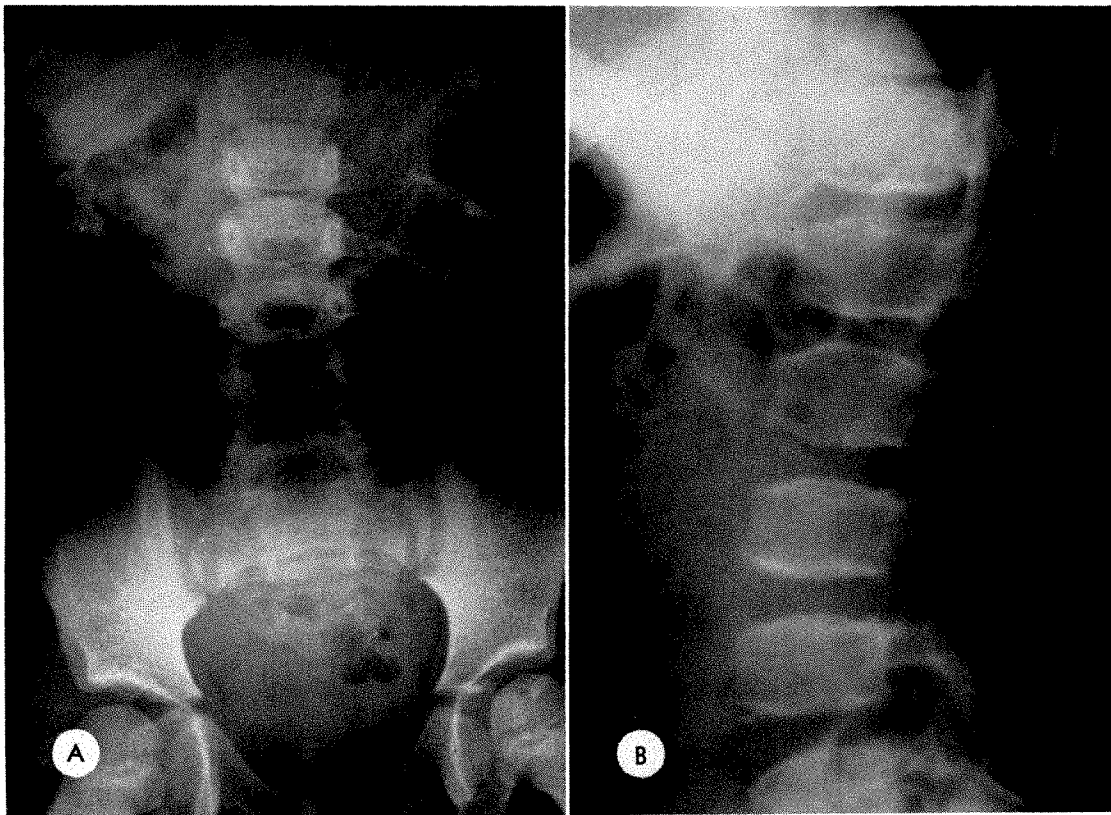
Case 1. Rightsided Wilms' tumor in an 8 week old girl. A dose of 3,300 r was given after resection. (A) Ten years later, the lumbar spine and pelvis show both distorted contour and hypoplasia. (B) Lateral roentgenogram of the lumbar spine shows irregularity and flattening of the centra.
